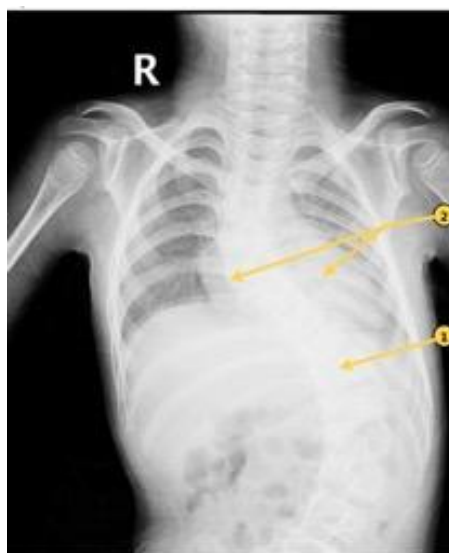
Preoperative frontal (anteroposterior) chest radiograph. (1) The cardiac silhouette is enlarged, predominantly toward the left; (2) bilateral perihilar bronchovascular markings are increased. These appearances are consistent with increased pulmonary blood flow in a child with congenital heart disease and should be correlated with echocardiography and the formal radiology report. The image is de-identified; patient identity is not shown.
